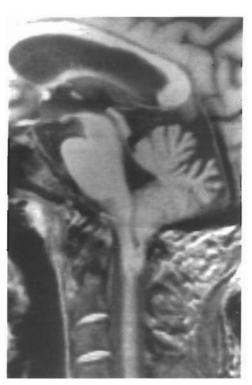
Magnetic resonance imaging of the head. Section with enlargement of infratentorial structures.
